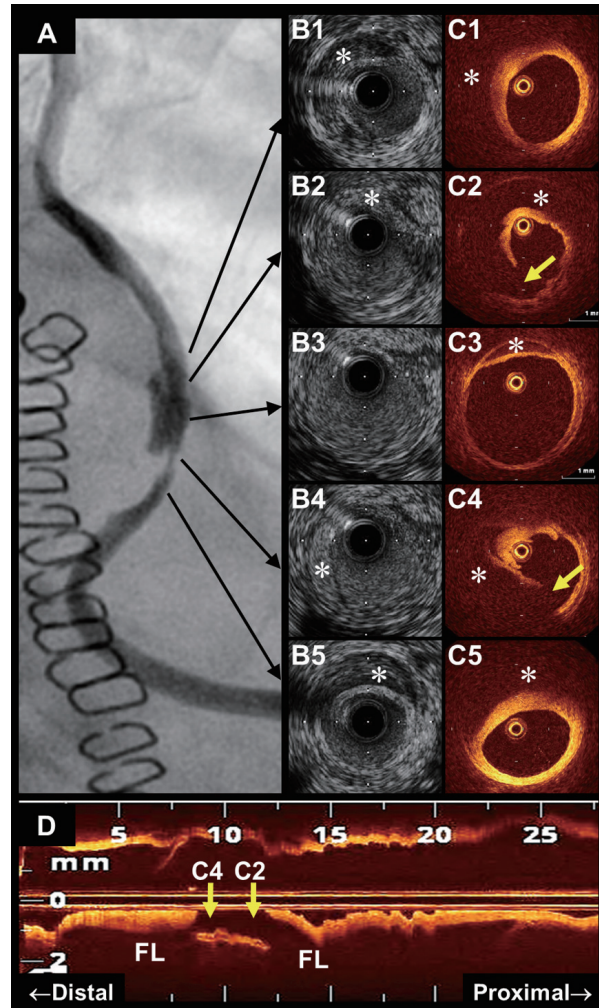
A: Angiography revealed severe stenosis that suggested dissection in the mid-portion of the left internal thoracic artery (LITA) graft. B1-B5: Intravascular ultrasonography showed intramural hematoma (*), but disruptions of the dissection flap were not detected. C1-C5: Optical coherence tomography (OCT) clearly showed intramural hematoma (*) and two disrupted dissection flaps (yellow arrows) at separate sites. Full images of the vessel wall were not seen in part because of attenuation caused by intramural hematoma on OCT. D: Longitudinal OCT image showed two false lumens (FL) extending proximally and distally from two disrupted sites (yellow arrows) corresponding to C2 and C4, respectively.
